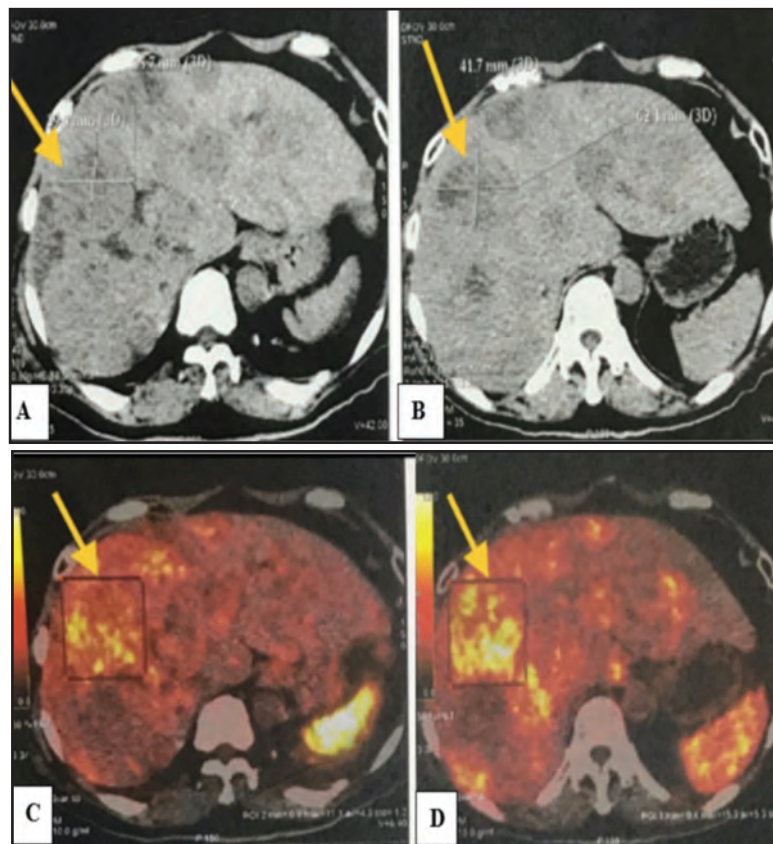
Ga-68 DOTATATE PET/CT scan showing heterogenous hypodense lesions throughout both enlarged and lobulated liver lobes with the largest lesion measuring 3.9 x 5.6 cm (A) before the surgery and it has increased in size measuring 4.2 x 6.2 cm (B) at 6 months post-surgery. Ga-68 DOTATATE PET/CT scan showing the tracer uptake by the largest lesion at segment VII with the SUV max of 11.1 (C) before the surgery and the intensity has increased with the SUV max of 15.3 (D) at 6 months' post-surgery. The liver lesions also have increased in number post-surgery.
